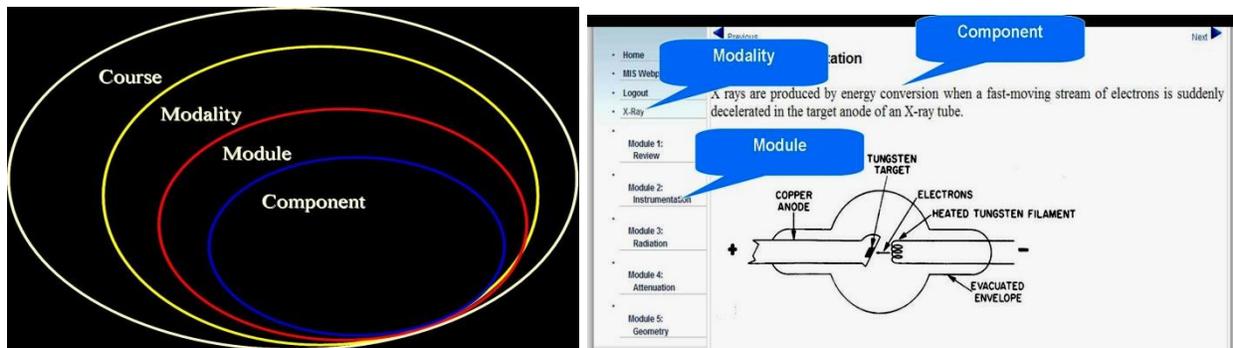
Medical imaging knowledge is built upon different scaled elements that are connected to each other. Left panel: Concept of nested medical imaging teaching/learning system. Right panel: Design example of the X-ray instrumentation within the X-ray imaging modality.
